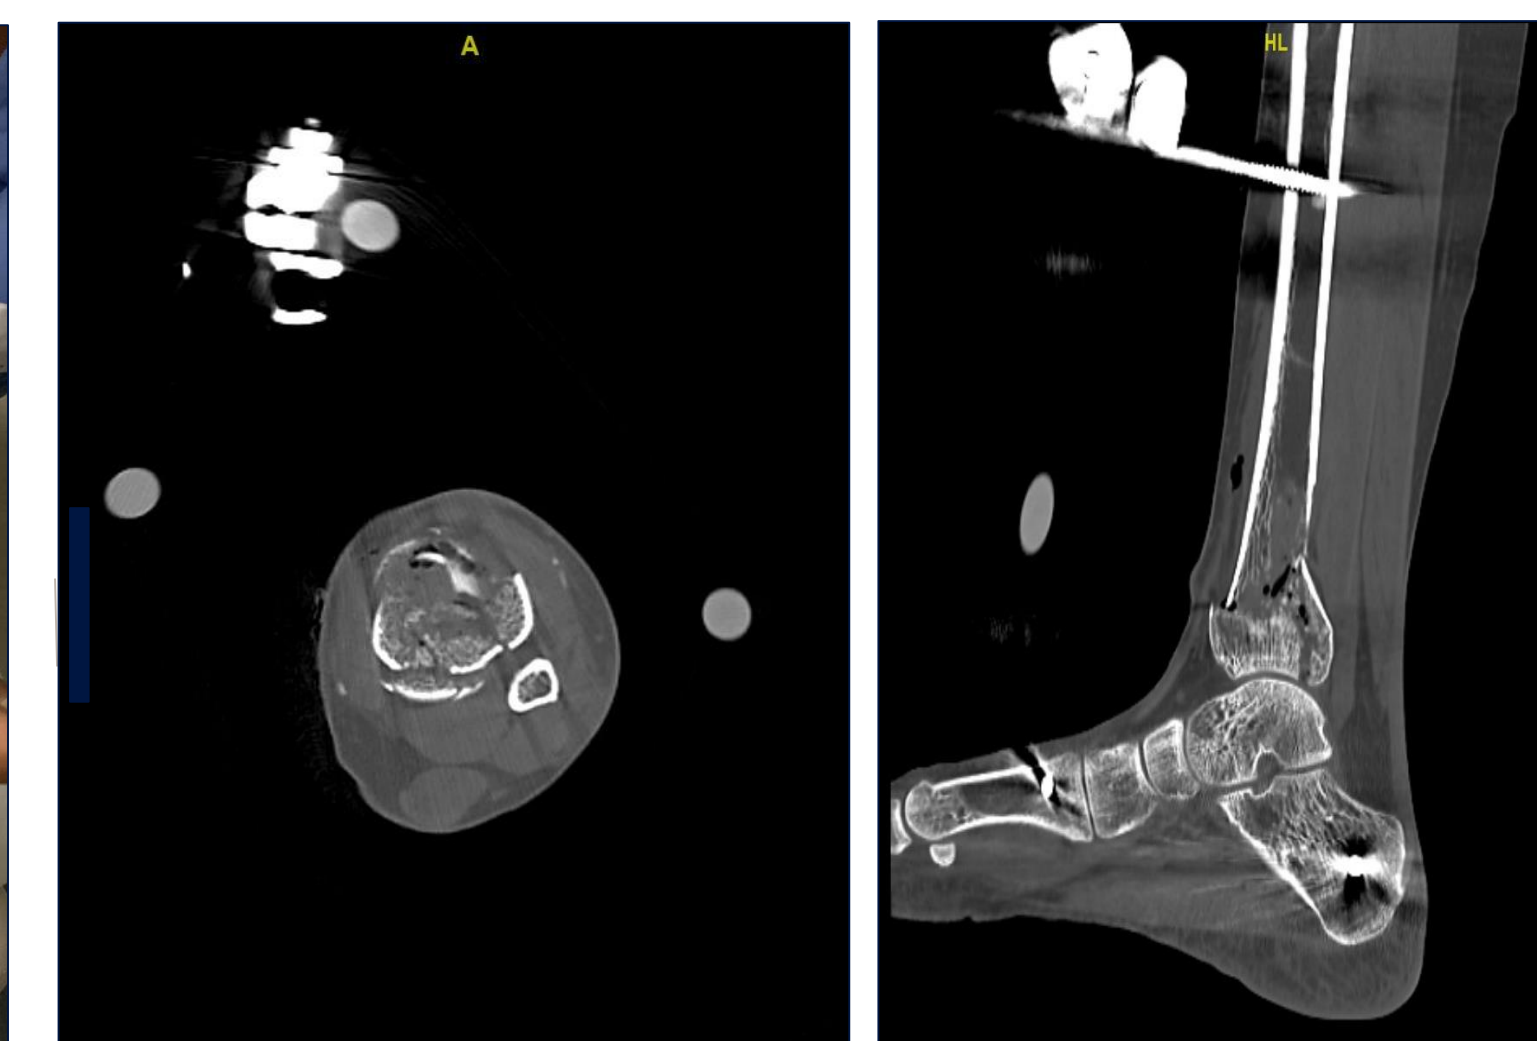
CT imaging after application of external fixation to further guide surgical planning.
